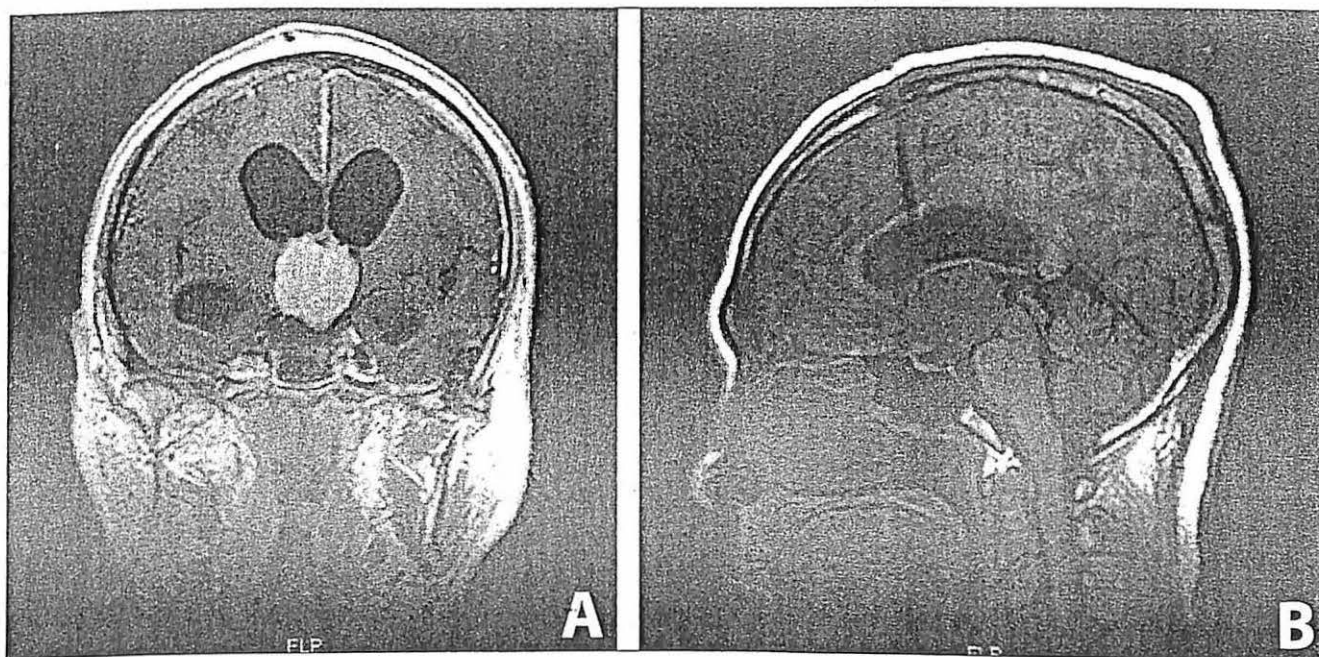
(A) Coronal magnetic resonance image of the brain, after gadolinium, showing an enhancing, rounded mass in the third ventricle obstructing the flow of cerebrospinal fluid at the foramen of Monro. (B) Sagittal T1-weighted image showing the mass of isointensity to the brain parenchyma occupying the anterior two-thirds of the third ventricle.
